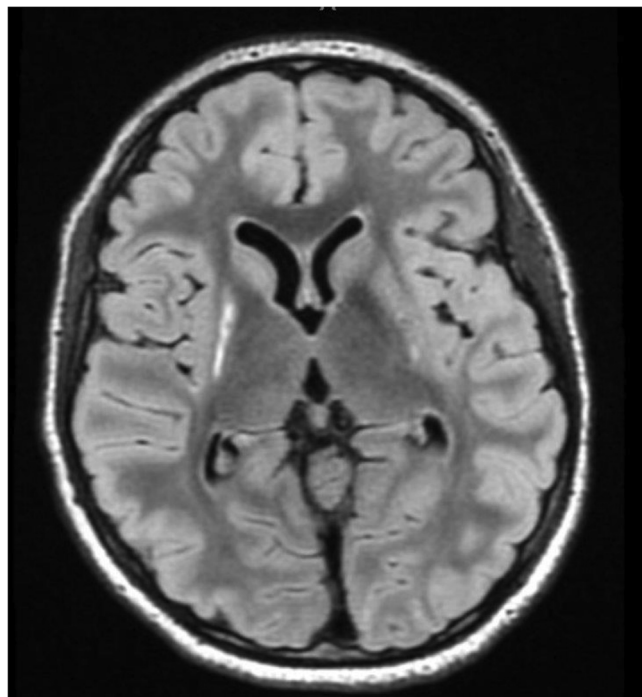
Axial fluid-attenuated inversion recovery (FLAIR) MRI. Ill-defined long T2 hyperintensity and minimal volume loss in the lentiform nuclei, head of caudate nuclei (right more than left); and ill-defined long T2 hyperintensity in the subcortical white matter of right posterior insula and right periorlandic region indicative of remote ischemic brain injury.
